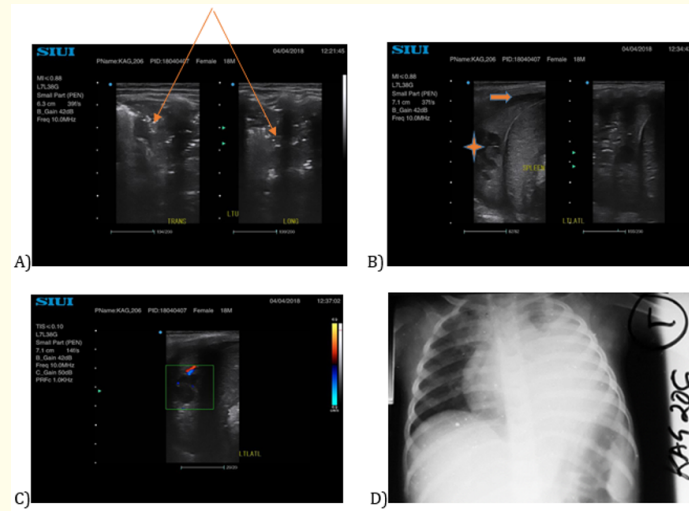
A case of left lung consolidation and its different features. An 18 months old admitted with pneumonia. A) A sonogram of the left anterior upper region showing a shred sign with dot-like echogenicities representing air bronchograms (arrows). B) Sonogram of the left lateral lower region showing, the diaphragm (echogenic curve), spleen, hypoechoic collection, arrowhead (pleural effusion) and part of the consolidated lung containing sonolucent areas, (star), which have no flow on color doppler in (C), signifying necrosis. D) AP radiograph showing a homogenous opacity in the left middle and lower lung zones forming a positive silhouette sign with the left cardiac border and obscuring the left costophrenic angle.
